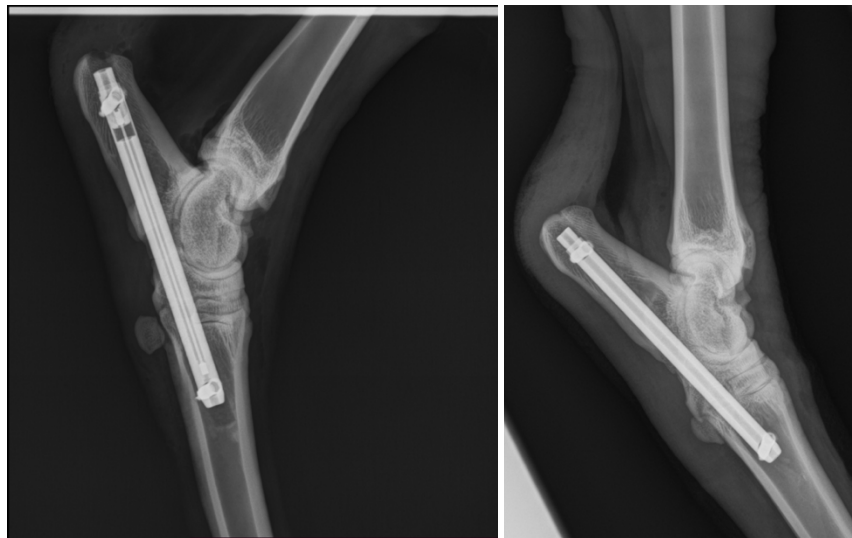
(left) Radiograph of dynamic device post-operatively. (right) Radiograph of static device post-operatively.
